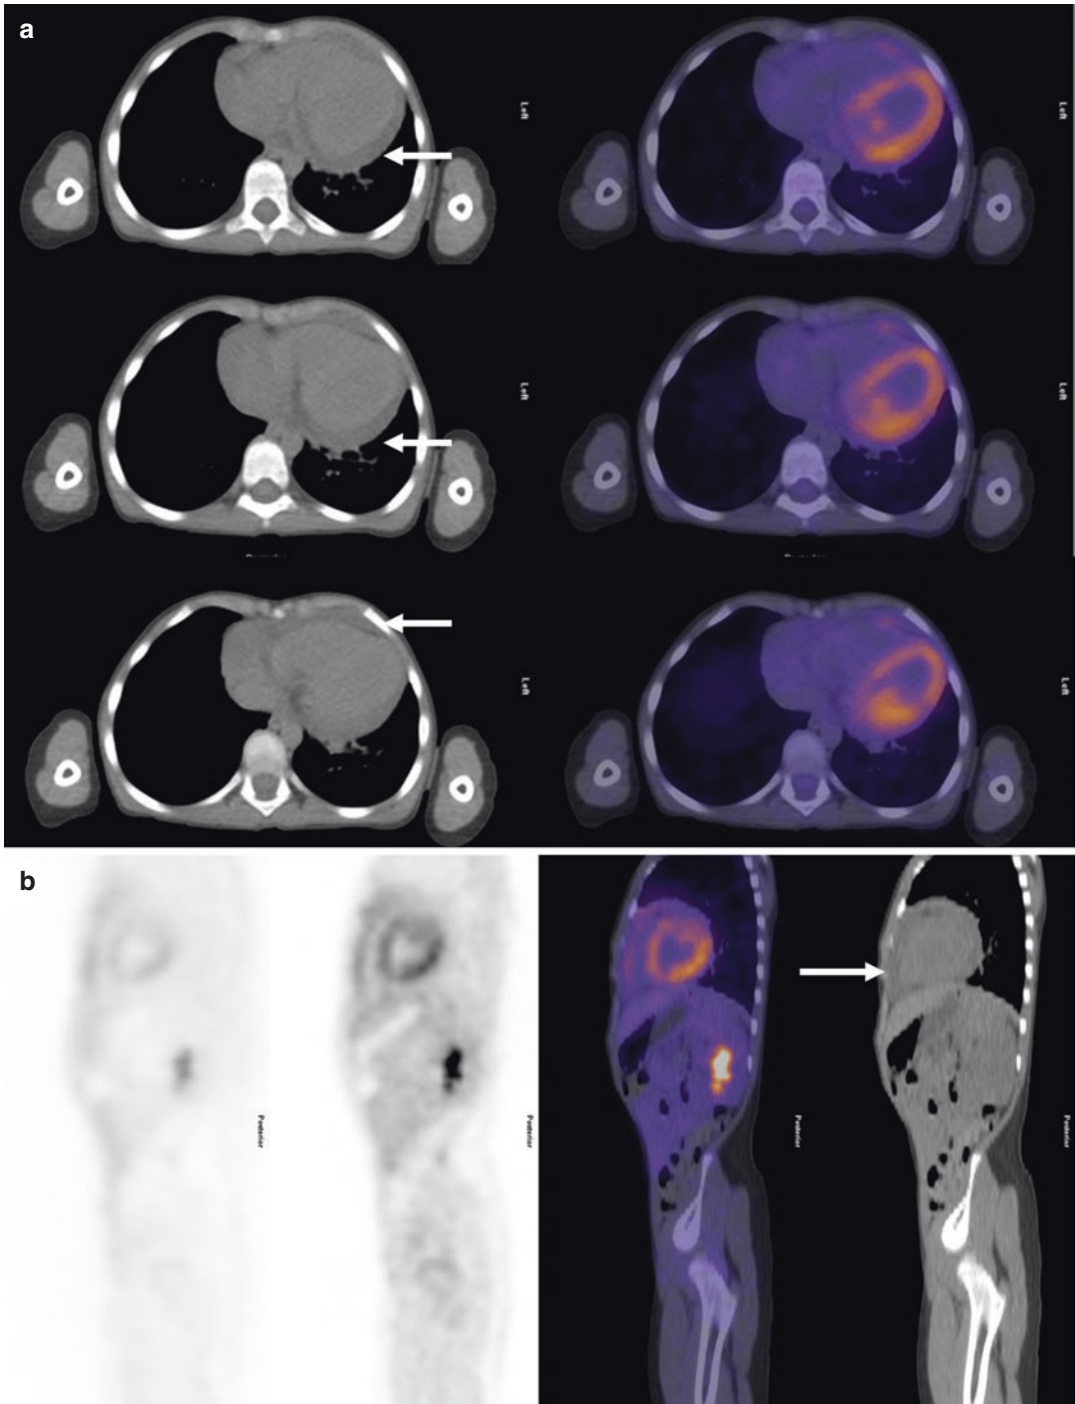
^{18}F -FDG PET/CT of a 5-year-old patient with a history of Kawasaki disease who presented with acute chest pain and heart palpitations. An echocardiogram demonstrated a pericardial effusion. ^{18}F -FDG PET/CT was requested to rule out collagen vascular disease as a
